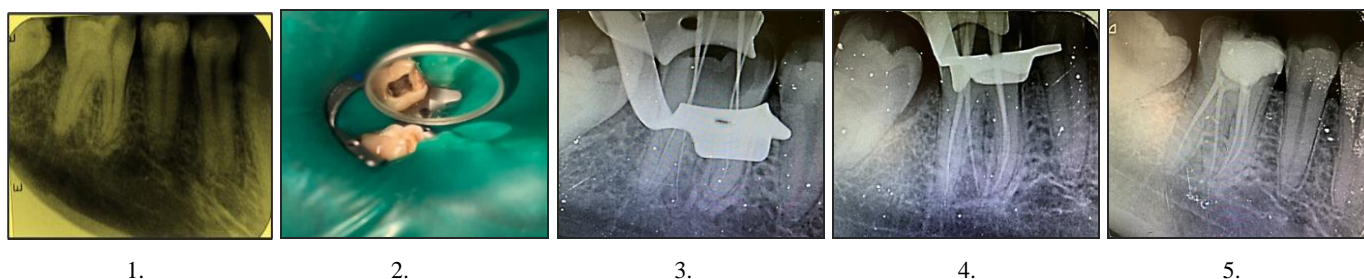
1. Preoperative radiograph of tooth 46 2. Access opening 3. Working length determination 4. Master cone 5. Completion of root canal treatment and permanent access restoration
